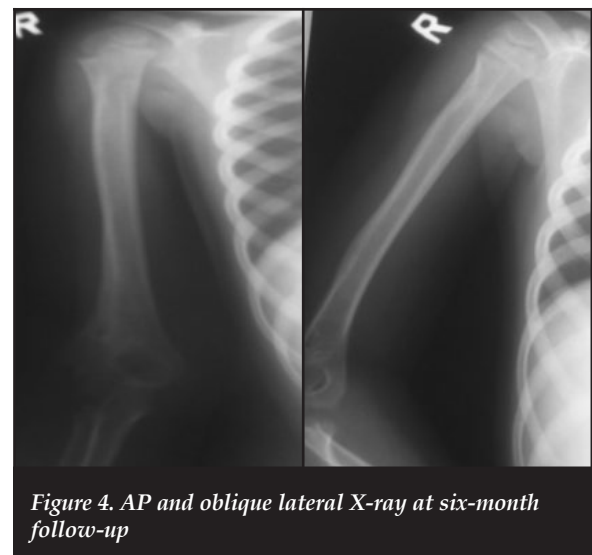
AP and oblique lateral X-ray at six-month follow-up
